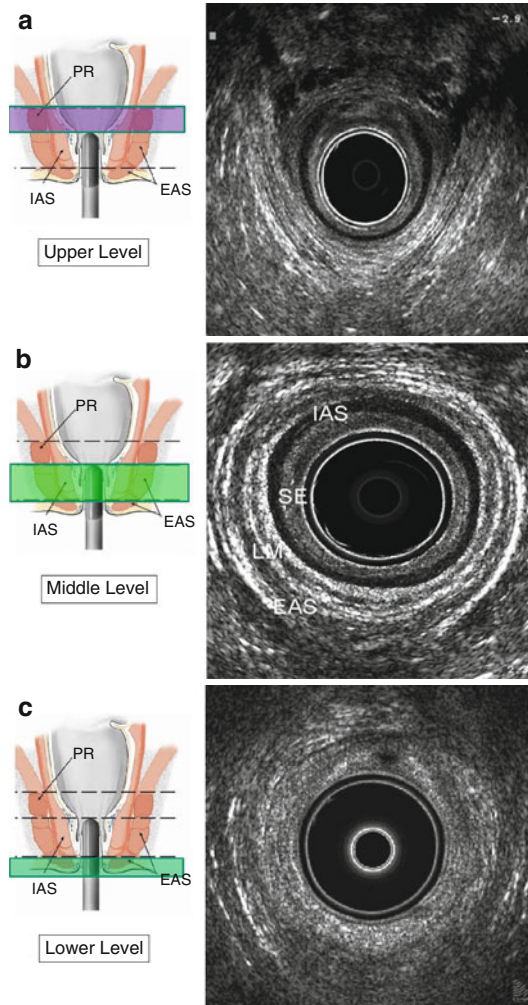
The ultrasongraphic three levels of the normal anal canal: (a) Upper level: the sling of the mixed echogenicity puborectalis muscle (PR). (b) Middle level: the subepithelial tissue, the hypoechoic ring of the internal anal sphincter (IAS), the longitudinal muscle (LM), the hyperechoic ring of the external anal sphincter (EAS). (c) Lower level: the subcutaneous part of the EAS
